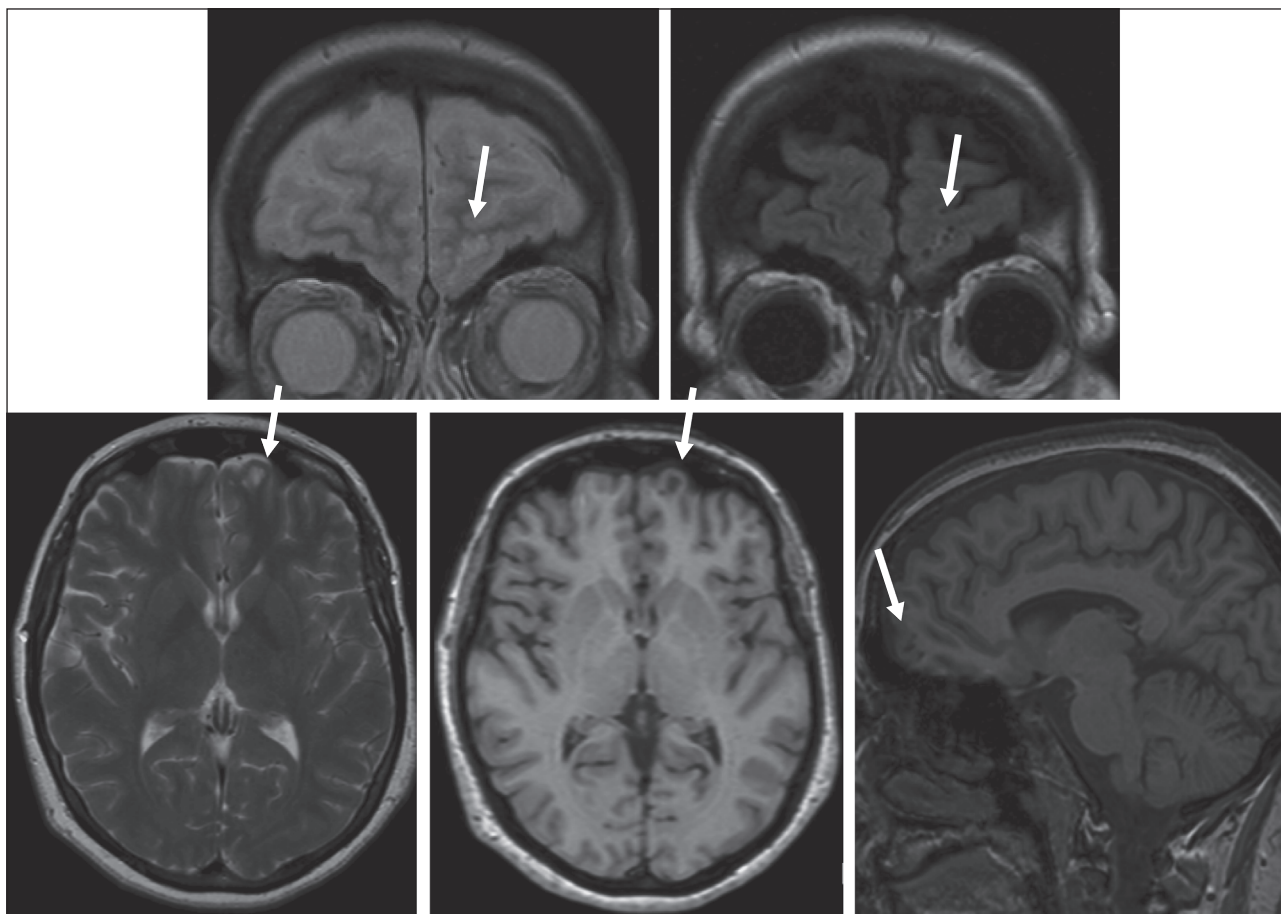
Brain MRI demonstrating a cystic lesion of the left fronto-marginal and inferior transverse fronto-polar gyri (white arrows).
